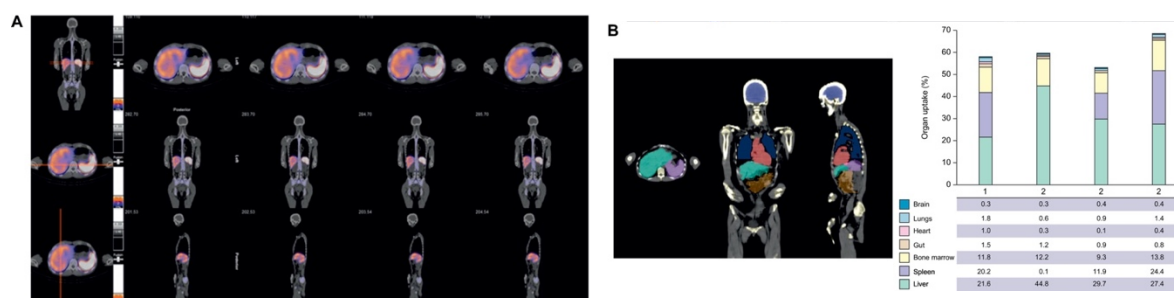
SPECT-CT axial, coronal and sagittal imaging of GMP-Tregs at 24hrs after infusion and cell distribution<sup>1</sup>
